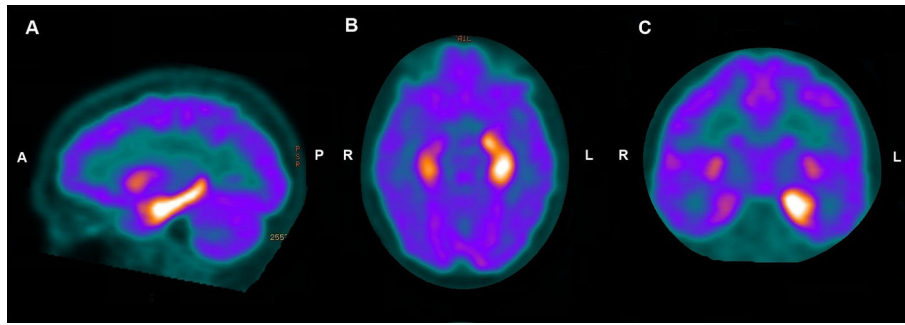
Brain 18F-FDG PET. Brain 18F-FDG PET, sagittal slide (A), axial slide (B) and coronal slides (C). A: Anterior. P: Posterior. R: Right. L: Left. Left predominant but bilateral medial temporal lobes and limbic system hypermetabolism in a patient with antiGAD67 antibodies is shown. Left hippocampus, fornix and cingulate cortex hypermetabolism can be seen in sagittal slides (A). Left predominant but bilateral hippocampus (B) hypermetabolism can be seen in axial slides. Left amygdala's hypermetabolism is evident in coronal slides (C).
